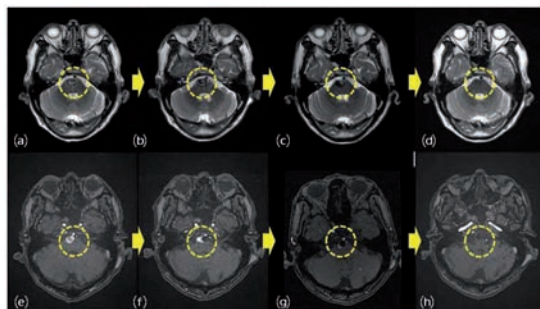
serial MRI image (a) initial T2WI, (b) post embolization 3 month, (c) after 2 months of 2nd embolization, (d) after 18 months follow up, (e) initial TOF, (f) partial occlusion and enlargement of Rt. Aneurysm sac, (g) decreased size of aneurysm, (h) disappeared aneurysm
